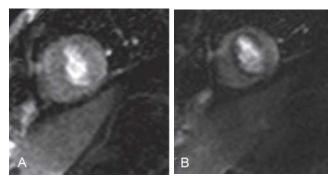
MRI in a 46-year-old woman presenting with exertional chest pain shows normal rest perfusion scan (A), but there is a dark band of hypoperfusion in the apical septal, anterior, and inferior walls in the stress image (B) consistent with ischemia in the distal left anterior descending territory.
